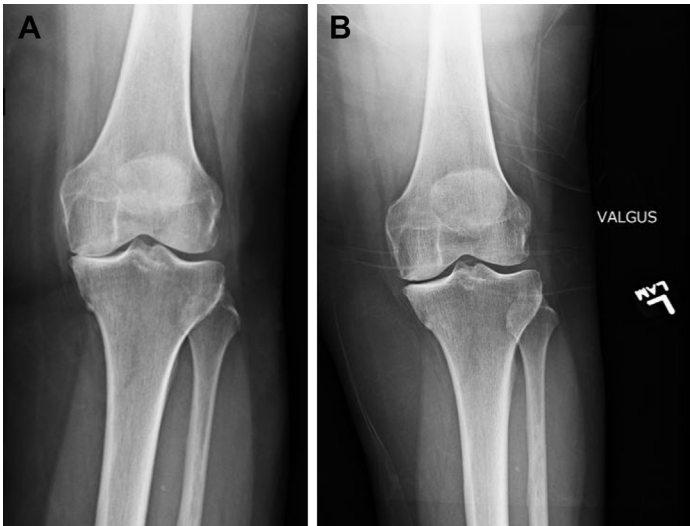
(A) Standing anteroposterior radiograph demonstrating medial joint space loss. (B) Valgus stress radiograph demonstrating correctable alignment and preservation of lateral joint space.
